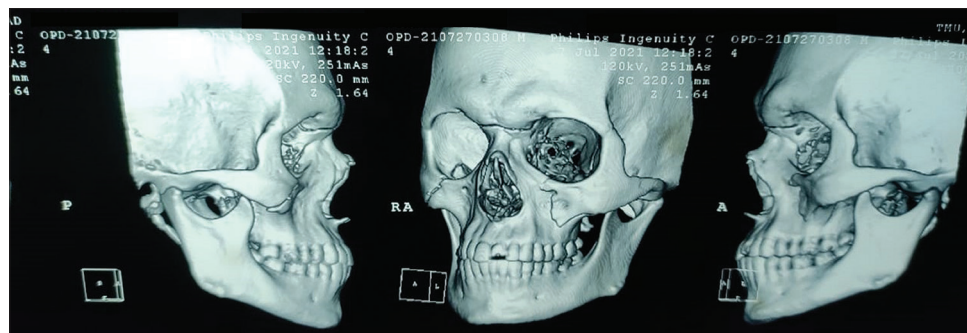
Computed tomography with 3D reconstruction showing fracture line below the frontonasal suture extending bilaterally to frontal process of maxilla, infraorbital margin, lateral wall of antrum, and pterygoid laminae
